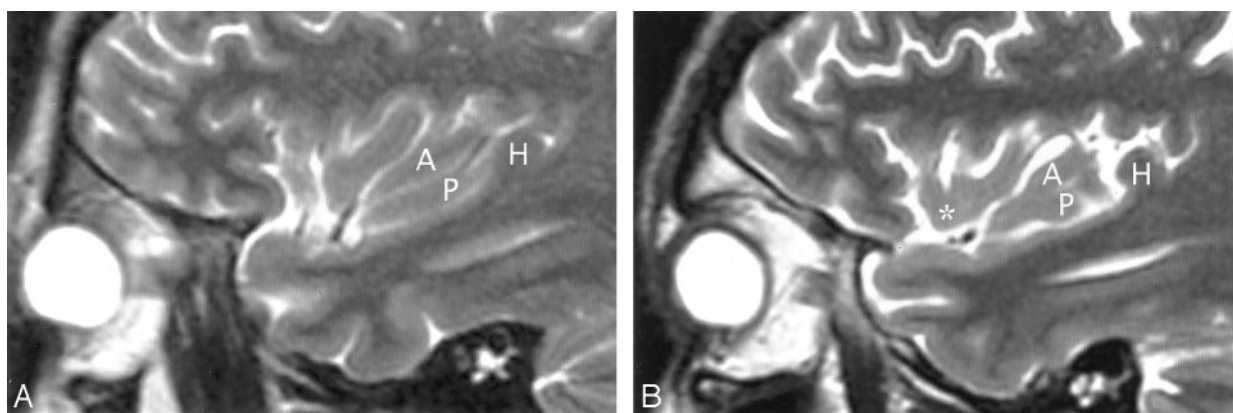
A and B, Imaging anatomy of the posterior lobule on sagittal T2-weighted MR images in a 13-year-old girl (A) and a 26-year-old man (B). In A, the ALG (A) and PLG (P) are well formed and distinct, correlating with Fig 1C. In B, ALG (A) and PLG (P) are poorly separated. PLG appears to bud off the posterior aspect of the ALG, giving the posterior lobule a branched configuration, such as seen in Fig 1B. Note the convergence of the short insular gyri to form the apex (asterisk in B) as seen in Fig 1B, the course of the CS posteroinferior to the apex en route to the stem of the sylvian fissure, the relationship of the pole of the posterior lobule to the limen, and the relationship of the HG (H) to both the PLG and the entire posterior lobule.
